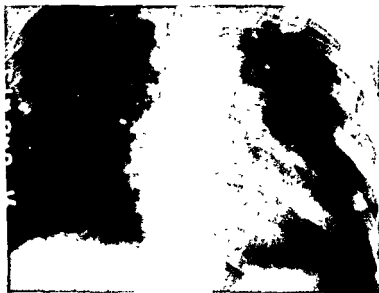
Right atrial myxoma in a 35 year old woman with tricuspid stenosis and recurrent chronic right heart failure. (A) Conventional frontal roentgenogram showing enlargement of the heart, especially the right atrium.
